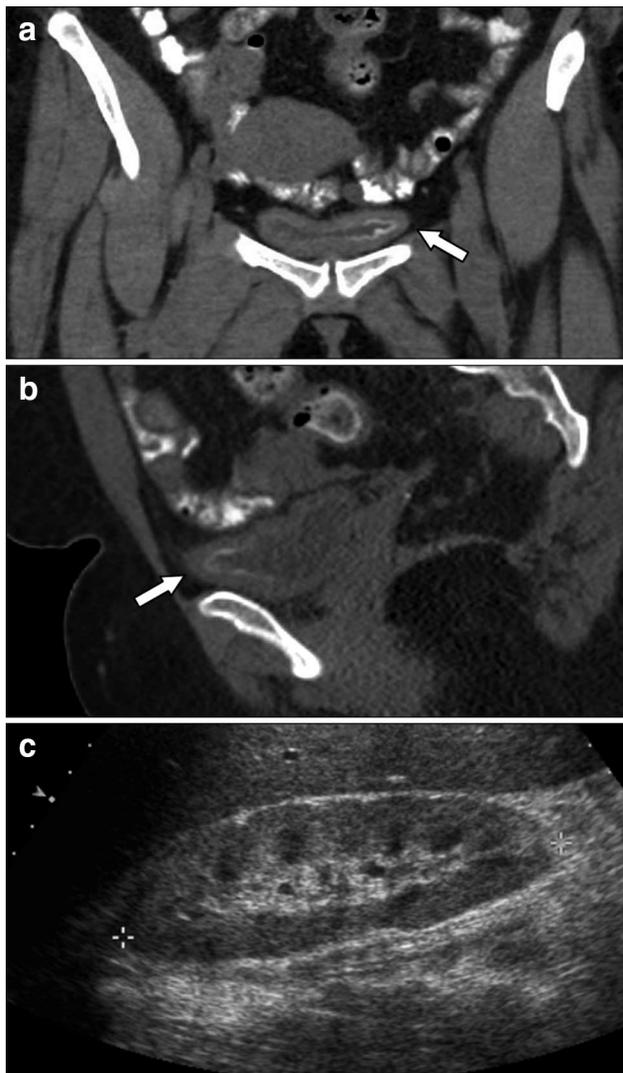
51-year-old woman with amyloidosis of the bladder. Coronal (a) and sagittal (b) non-contrast CT images demonstrates asymmetric bladder wall thickening and calcification (arrows). Case courtesy of Victoria Chernyak, MD, Montefiore Medical Center. c 55-year-old man with amyloidosis of the kidney. Ultrasound demonstrates renal enlargement, increased echogenicity in the renal cortex and prominent medullary pyramids. Case courtesy of Hebert Alberto Vargas MD, Memorial-Sloan Kettering Cancer Center
